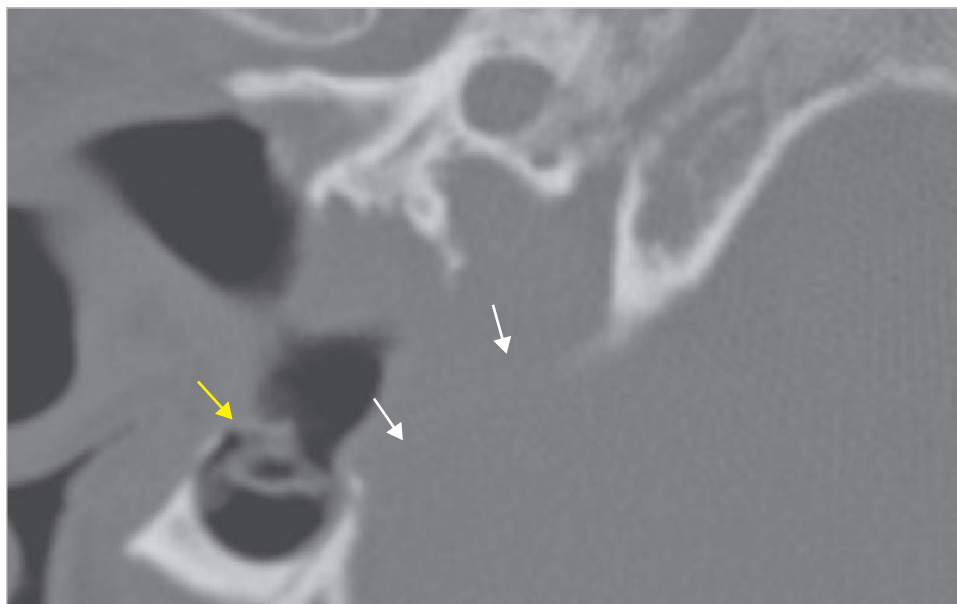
The patient underwent middle ear surgery elsewhere, and intractable otorrhea follows. The axial CT shows extensive destruction of temporal bone and accumulation of debris in inaccessible area (*yellow arrow*). The posterior fossa dura and the area of the sigmoid sinus are exposed extensively (*white arrows*).
